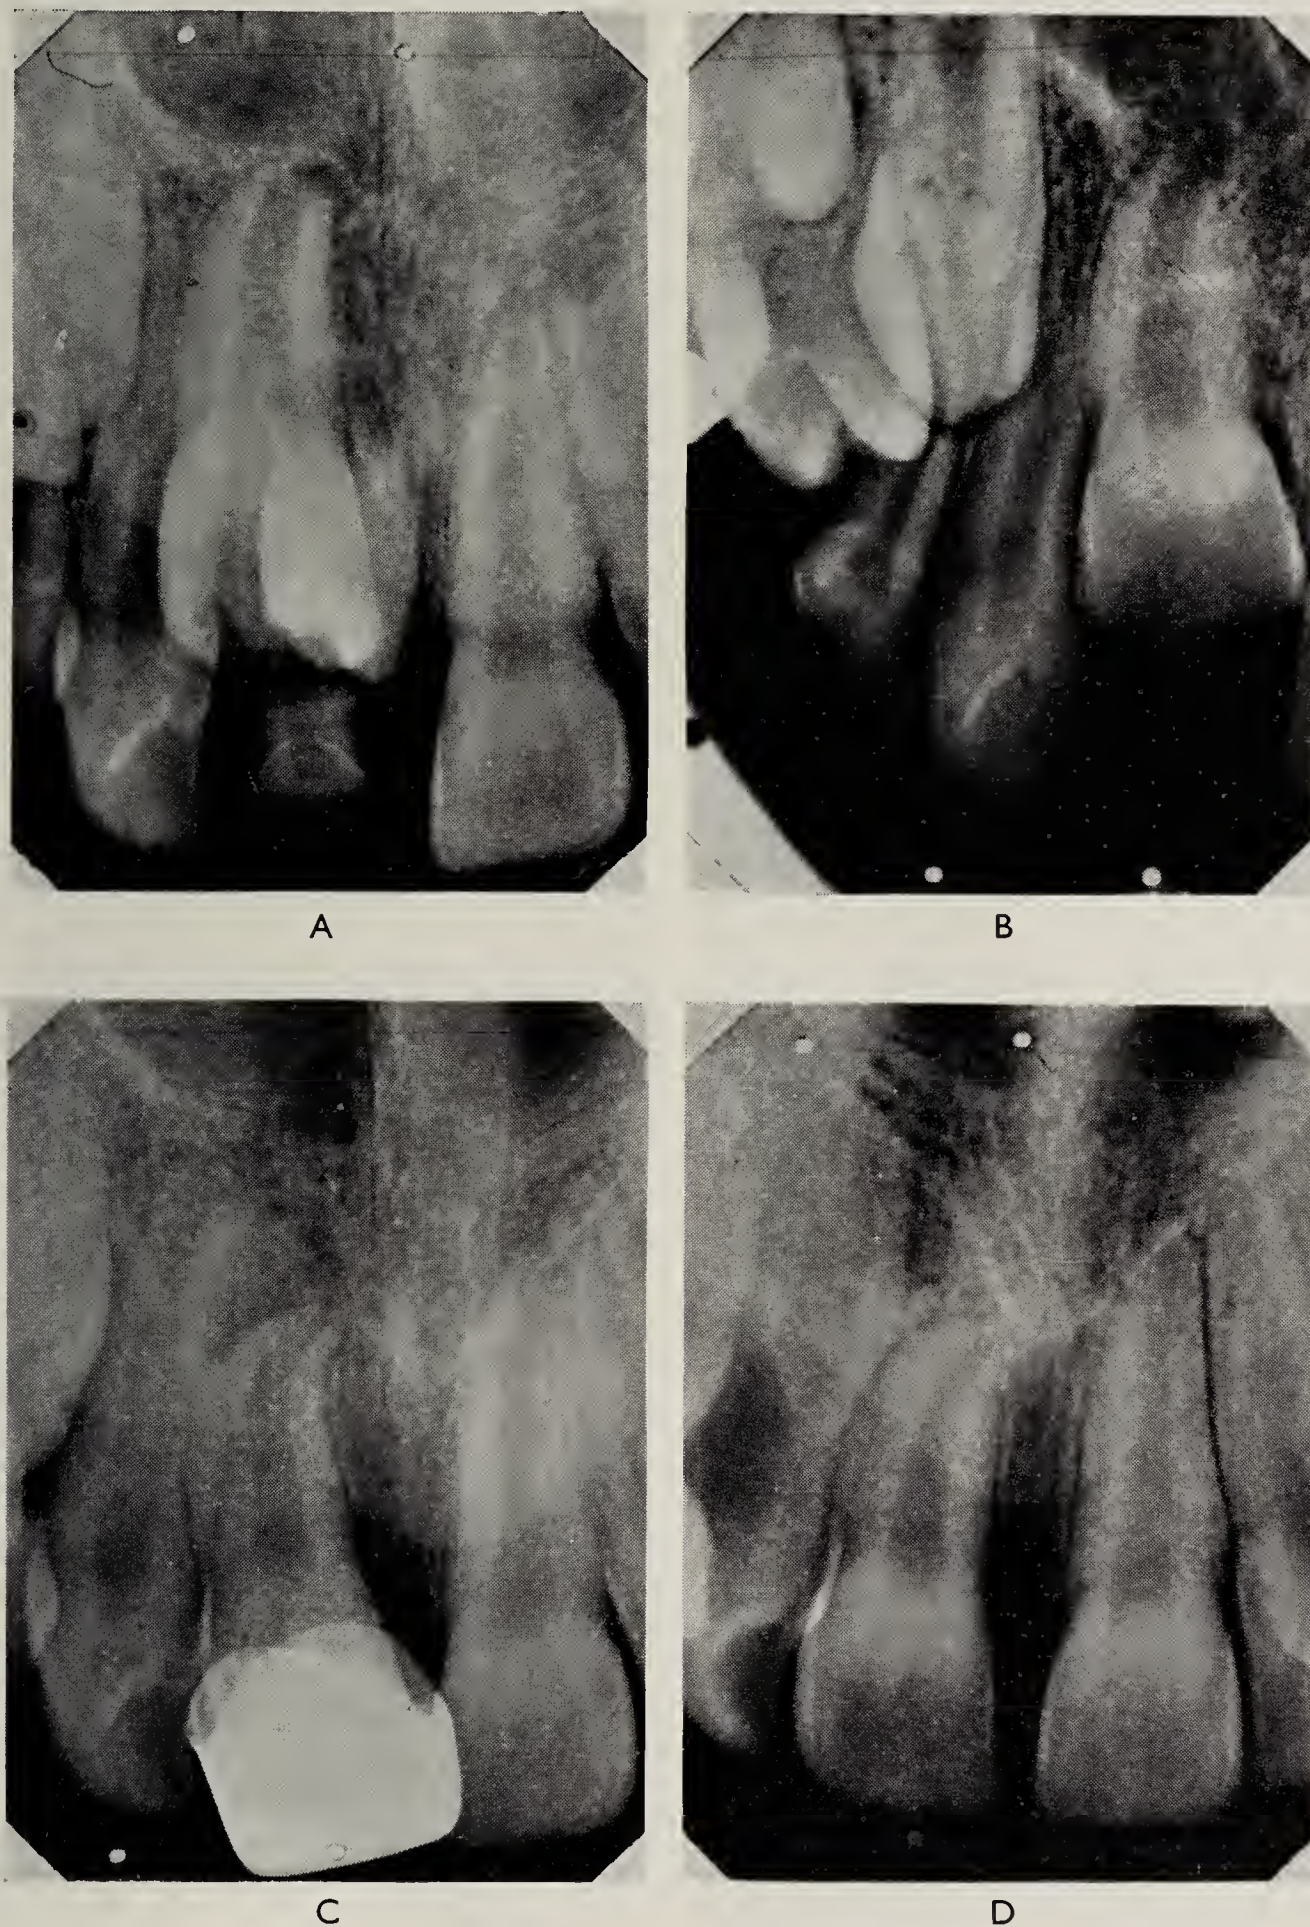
Case 4. Invaginated supernumerary. A, Preoperative X-ray; note space between crown of 11 and root of 11. B, One year later 11 crown now appears to be in close apposition to 11 root. C, Four months after capping. D, Six months later 11 apex complete; terminal root deformation apparent.
